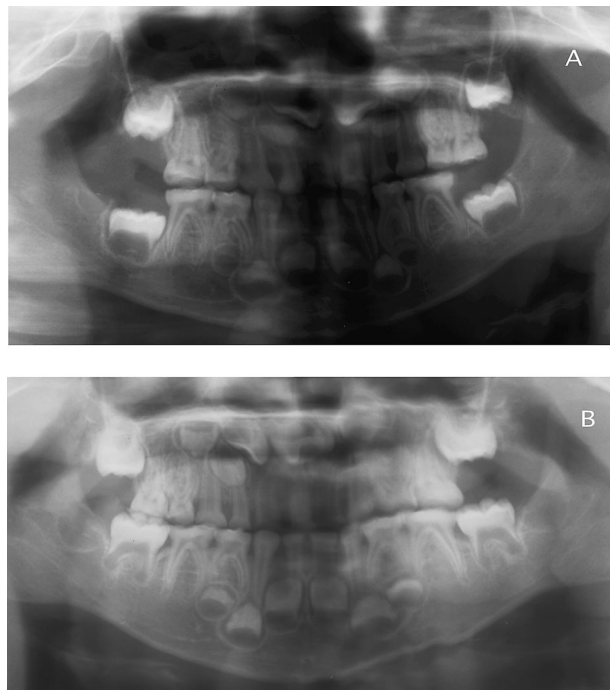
Panoramic radiographs of the patient
